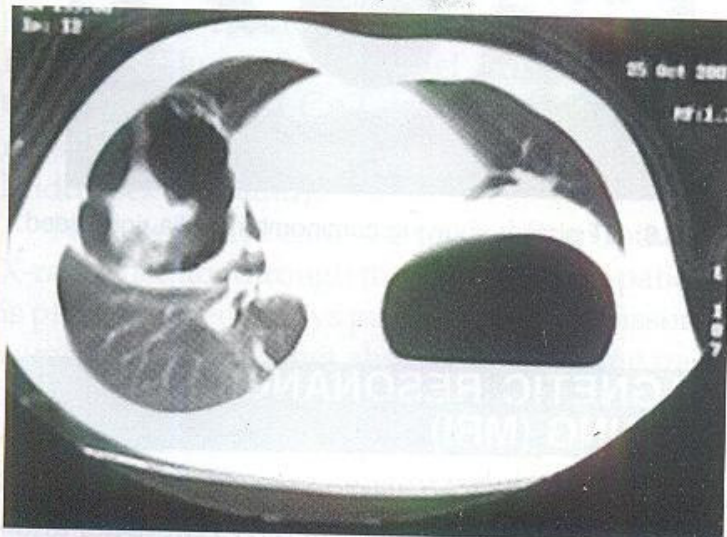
CT scan chest showing lung abscess right side.
